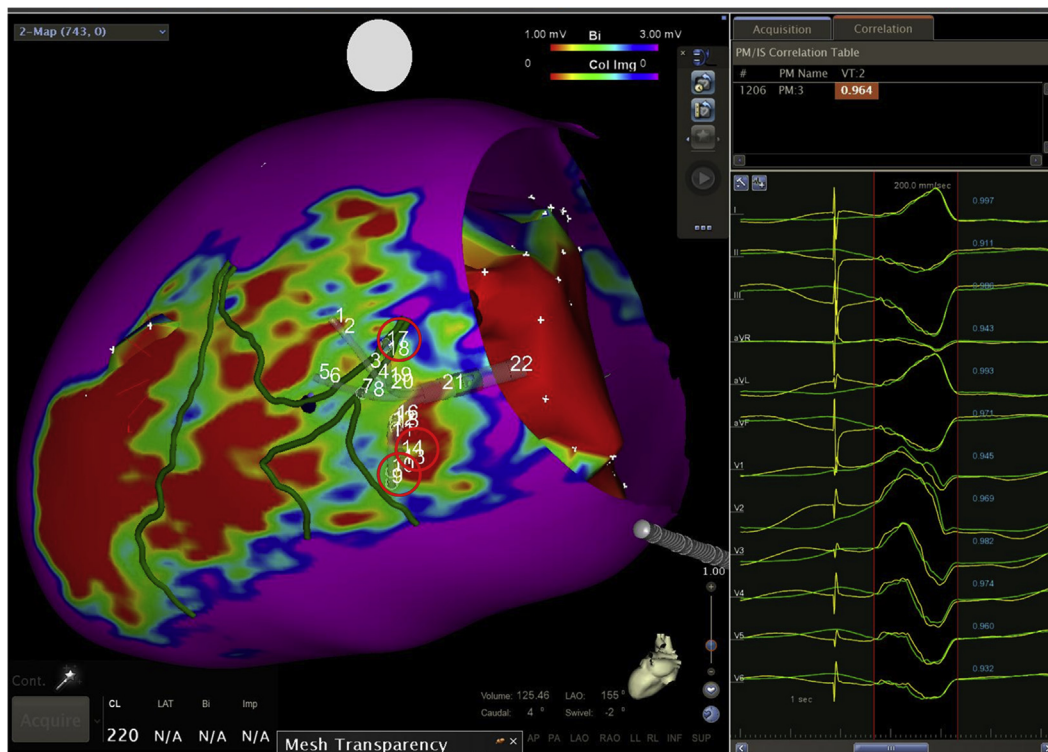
Three-dimensional scar reconstruction of a high-resolution late gadolinium-enhanced cardiac magnetic resonance image merged with the CARTO-derived electroanatomic voltage map. The position of the PentaRay catheter is demonstrated, with red circles indicating respective electrodes in the ventricular tachycardia channel from the entrance to the exit: 17-18, 13-14, and 9-10. Green lines indicate conducting channels as detected on late gadolinium-enhanced cardiac magnetic resonance images (left); pace map from electrodes 13-14 resulted in a PaSo score of 96.4% (right).
